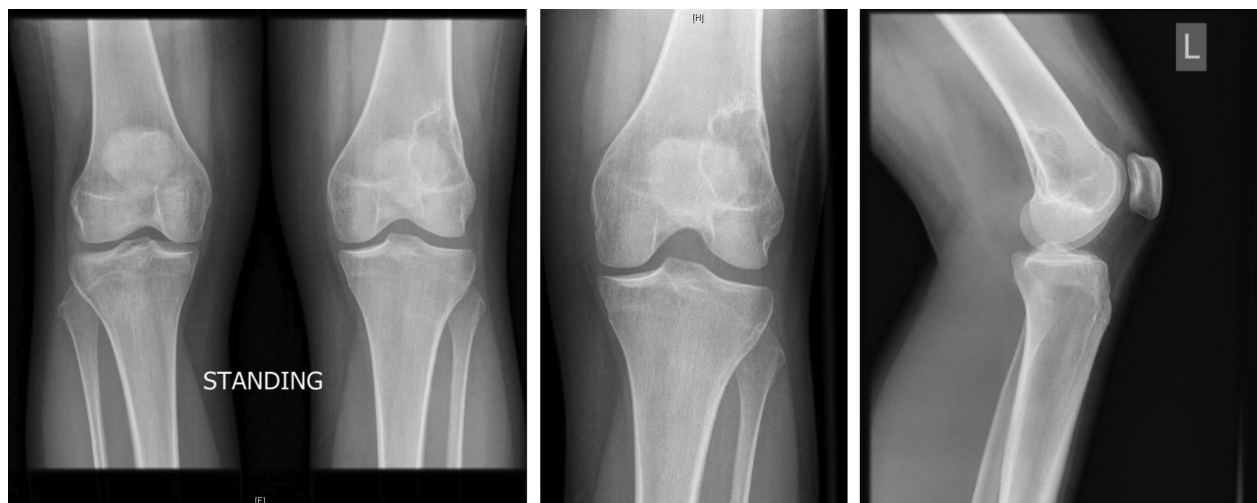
Radiographs—bilateral anteroposterior, unilateral anteroposterior, and lateral views of the left knee. Note an eccentric bone lesion of the left distal femur with a sclerotic rim and a narrow zone of transition.
